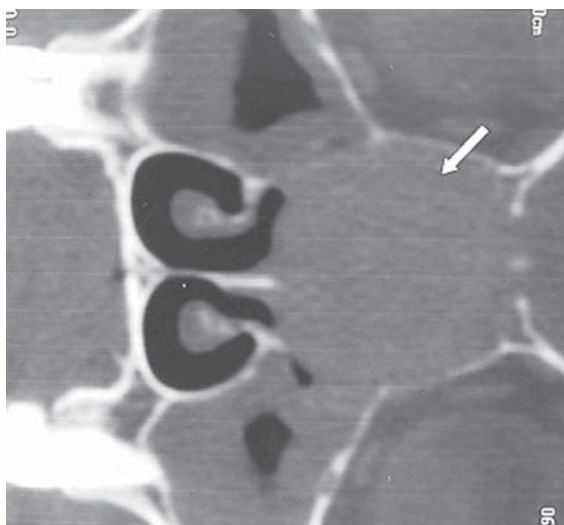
Coronal CT image of the mass reveals the lack of mineralization of osteoid or chondroid type (arrow).
